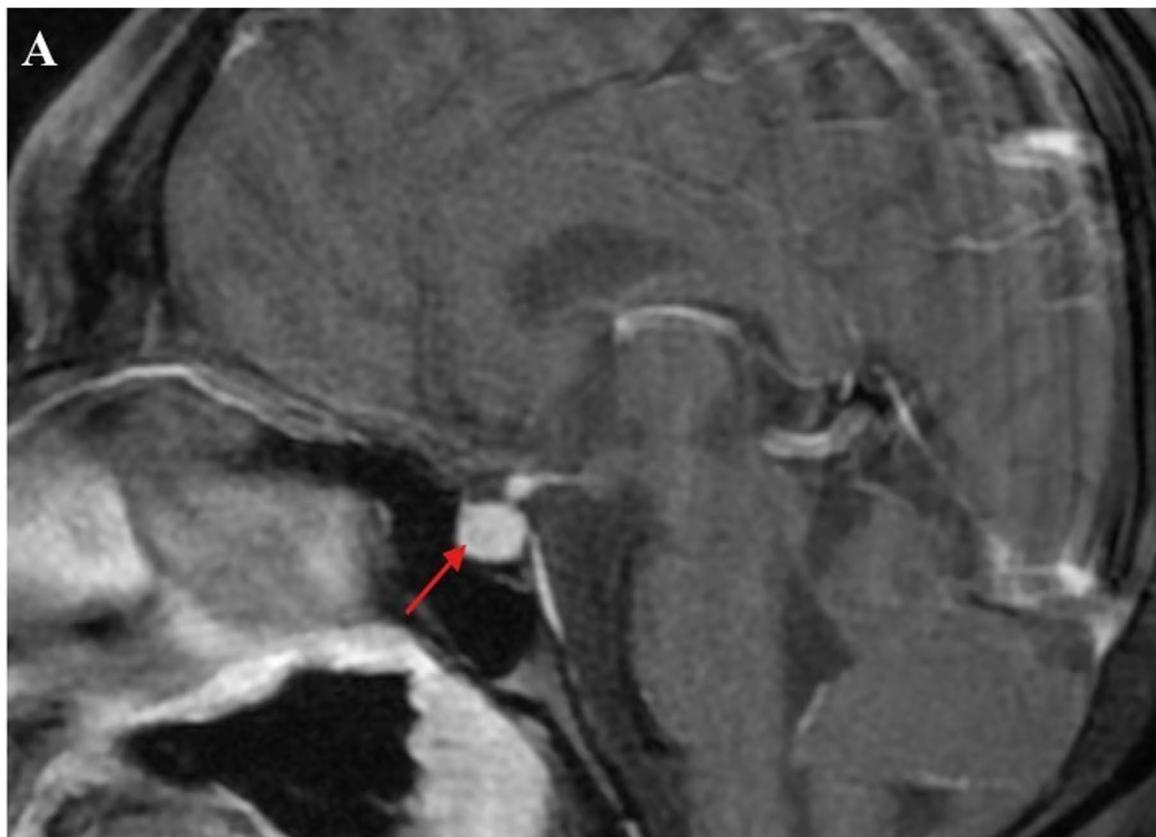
Sagittal (A) and coronal (B) sections of the sellar MR image showing a microadenoma of the pituitary (red arrows)
